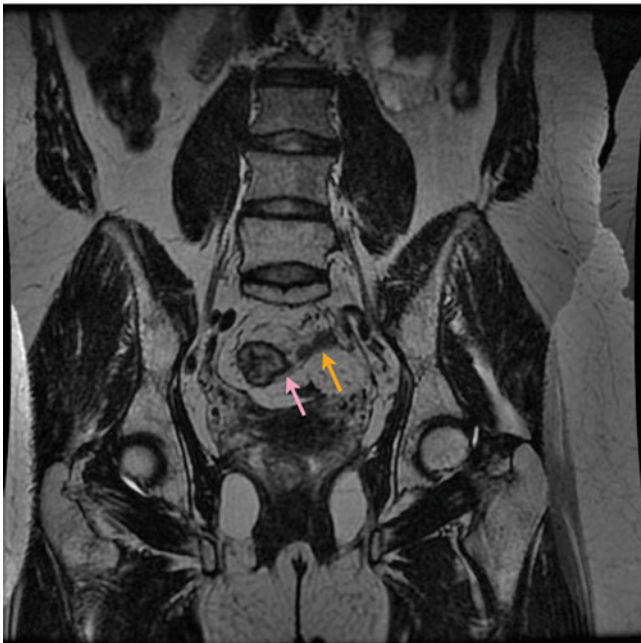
Magnetic resonance of a patient with a complete clinical response but mixed signal intensity (arrow) within the rectal wall. PET/CT showed FDG uptake and radical surgery confirmed the presence of residual cancer ypT2N0
